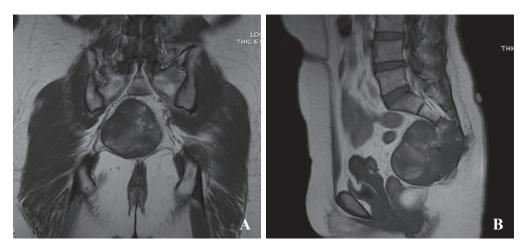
Show T-1 weight MRI, A: coronal view, B: saggital view
